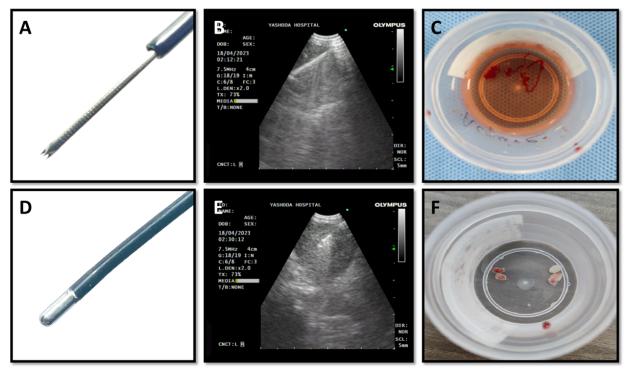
A) Image of franseen Acquire biopsy needle showing the three pointed cutting edge; B) EBUS sonographic image with the Acquire biopsy needle within the lymph node; C) image showing linear cores obtained using Acquire biopsy needle; D) image of the 1.1 mm cryoprobe; E) EBUS sonographic image with the cryoprobe within the lymph node; F) image showing the nodal cryobiopsies obtained using the 1.1 mm cryoprobe.
